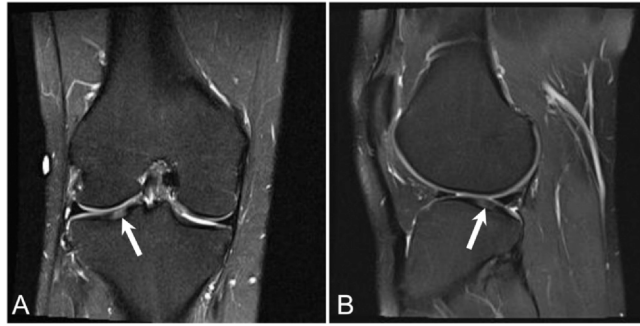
Elite football defensive end presents for a baseline knee MRI as part of a pre-employment physical. Coronal T2 FS (A) and sagittal T2 FS (B) MR images show an area of cartilage edema and heterogeneity (arrow) at the medial aspect of the lateral tibial plateau. These low-grade chondral lesions may be reflective of chondropenia and occur in the professional athlete over time due to the intense, repetitive forces experienced at the weightbearing joint surface during play. Although such lesions may be incidental and asymptomatic, they can progress to higher-grade chondral lesions in the future. Anecdotally, this finding at the lateral tibial plateau is frequently seen and may be due to normal variations in the hyaline cartilage composition. FS, fat saturation; MR, magnetic resonance; MRI, magnetic resonance imaging.
